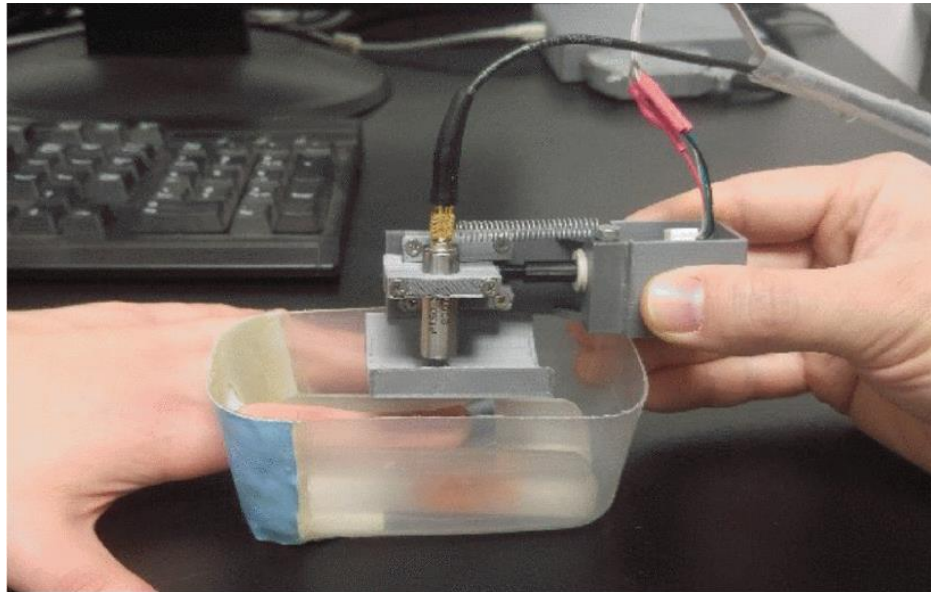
Experimental setup for fingernail properties assessment. The ultrasound transducer mounted into a micro scanner with a displacement actuator.
